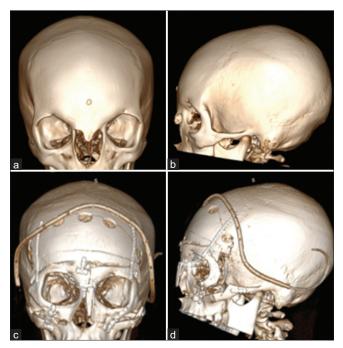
(a-b) Pre- and (c-d) 1-day postoperative cranial CT scan of patient 2.
